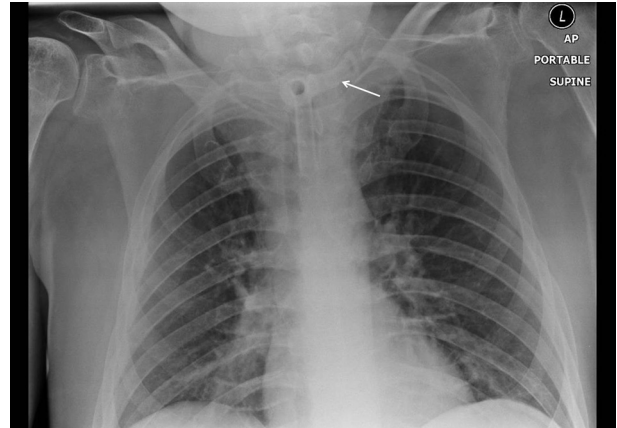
AP chest X-ray of a recovering patient on the ICU with a tracheostomy in situ. Note the external strap to secure the airway, projected over the patient's neck.
